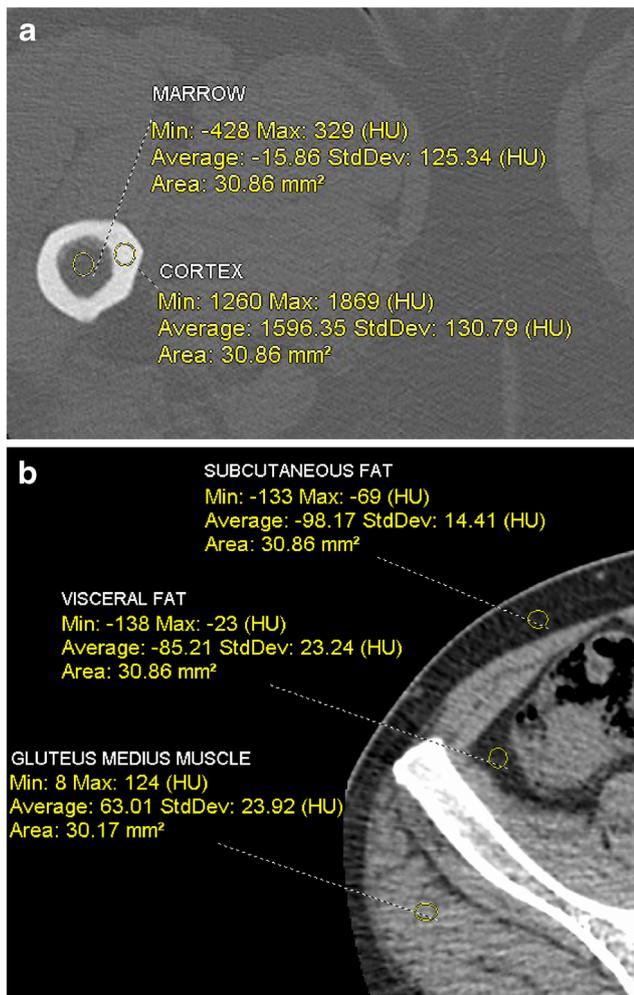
Sample region of interest Hounsfield units and standard deviation measurements on axial pelvis CT. a Femoral cortex and marrow on bone windows. b Gluteus medius muscle, visceral fat, and subcutaneous fat on soft-tissue windows
